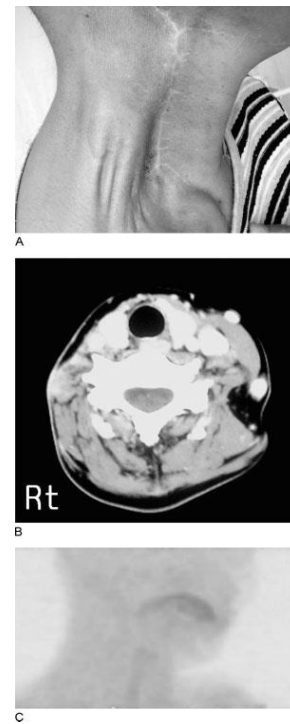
(A) Local appearance 12 months after BNCT. (B) The tumor region was cicatrized on CT performed 12 months after irradiation. (C) ^{18}F BPA PET performed 12 months after irradiation. No accumulation of BPA in lesion was noticed (images reprinted with the permission of the editor, license number 2762421391809).
